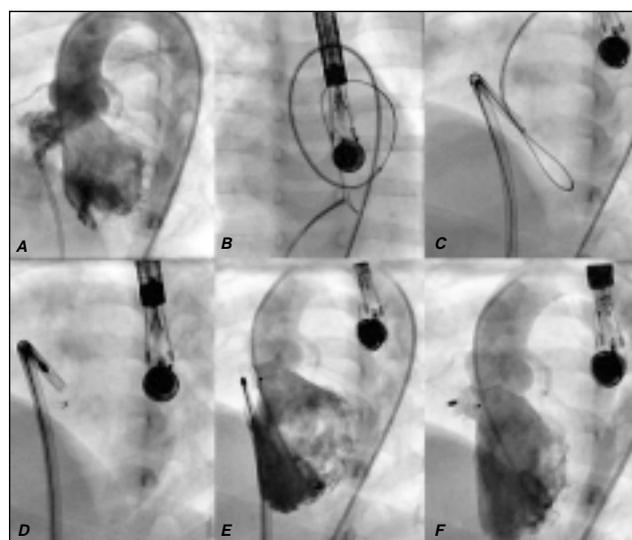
Steps in transcatheter closure of PMVSD with AAVSDO: (A) Left ventricular angiogram in long axial oblique view showing perimembranous VSD, (B) Cine-radiographic frame showing the 0.032" exchange length wire being snared from the pulmonary artery to form an arteriovenous wire loop, (C) Cine-radiographic frame showing the sheath deflected into left ventricle with a wire loop formed by introducing the 5F RCA catheter into the left ventricle from the aorta, (D) LV disc deployed with the marker toward the apex, (E) Angiogram in long axial oblique view showing the device in position before release, (F) LV angiogram in long axial oblique view showing the device in position after release.
